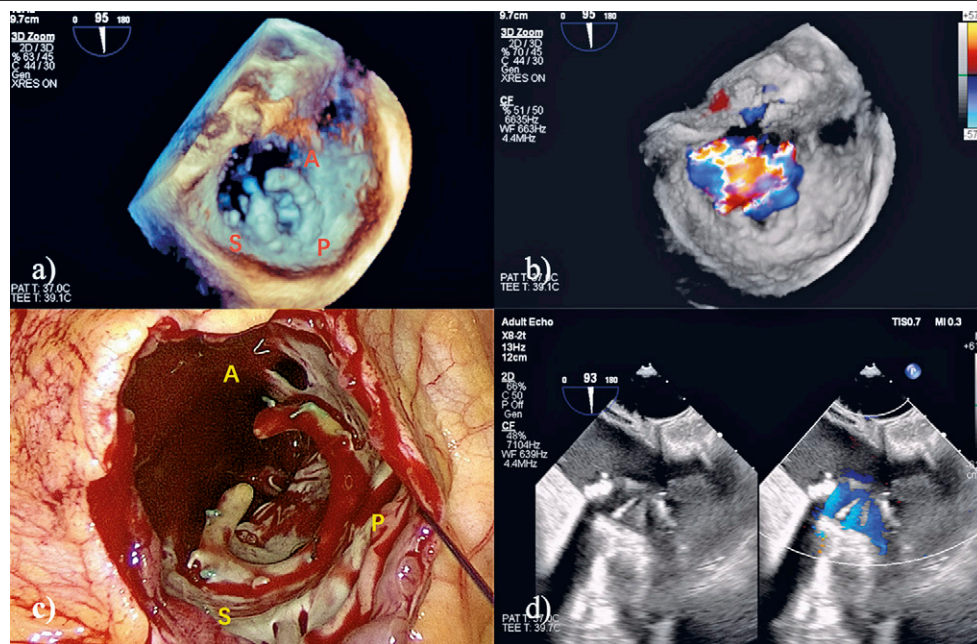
a) Intraoperative real-time 3D TEE showed tricuspid annulus dehiscence; b) the 3D TEE showed that a large amount of tricuspid regurgitation comes from outside the tricuspid annuloplasty ring; c) intraoperative exploration revealed severe tearing of the anterior and septal leaflets of the tricuspid valve, resulting in complete detachment from the tricuspid rigid ring; d) the mechanical tricuspid valve replacement was performed. TEE, transesophageal echocardiography; A, tricuspid anterior leaflet; S, tricuspid septum leaflet; P, tricuspid posterior leaflet.
